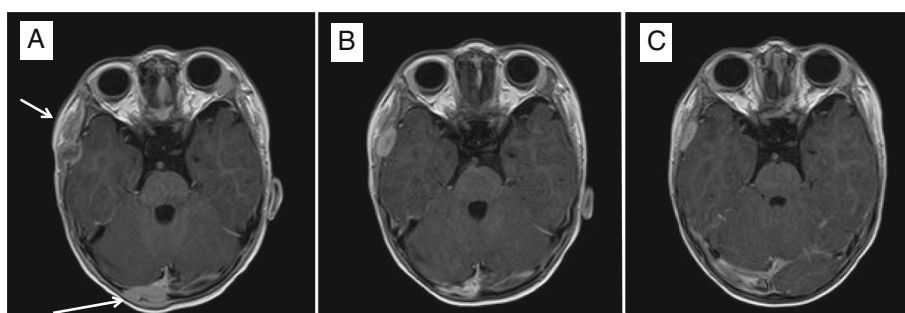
MRI Axial view (seq. esT1W_3S_FFE post-contrast). Intracranial lesions of the right temporal and right parieto-occipital regions (bars). a Before sunitinib treatment. b Day + 56 of sunitinib. c Day + 156 of sunitinib
